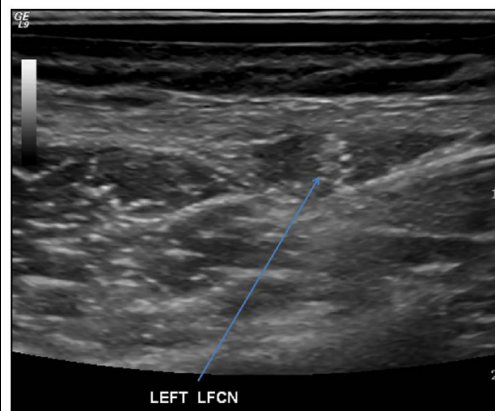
High resolution Ultrasound showing the left lateral femoral cutaneous nerve (LFCN) inbetween the 2 layers of fascia, superficial to the sartorius muscle
